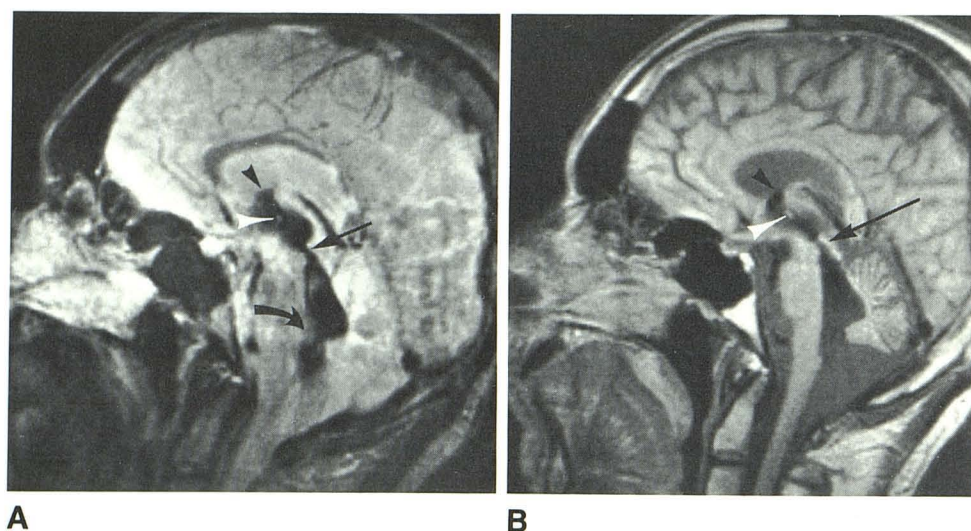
37-year-old man with inferior vermal dysgenesis and posttraumatic EVOH. Basilar subarachnoid spaces are enlarged. Midsagittal MR scans are 5 mm thick. A, T2-weighted scan (SE 2200/80). CSF in lateral ventricles is bright. Striking CFVS in foramina of Monro (black arrowhead), third ventricle, aqueduct of Sylvius (straight arrow), fourth ventricle, and foramen of Magendie (curved arrow). CFVS surrounds massa intermedia (white arrowhead). B, T1-weighted scan (SE 750/40). CFVS is less well seen but is present in foramina of Monro (black arrowhead), posterior third ventricle, aqueduct of Sylvius (arrow), and proximal fourth ventricle. Massa intermedia (white arrowhead).
